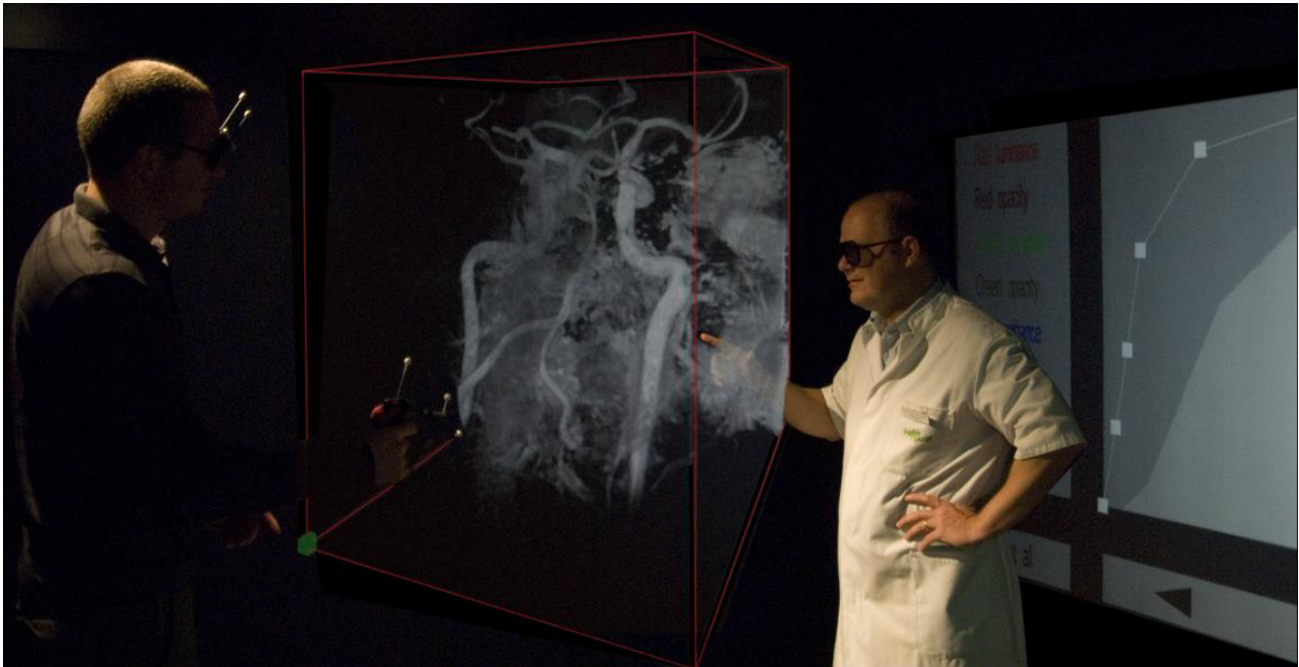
Carotid arteries as imaged with a 7 Tesla MRI scanner are being visualized in the Erasmus MC I-Space.
